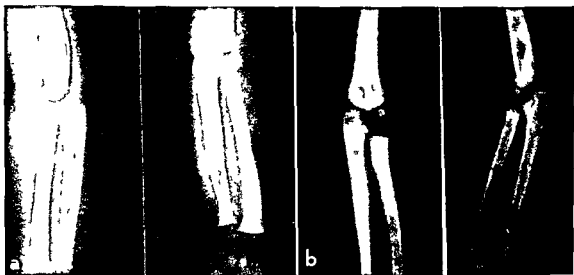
Osteochondritis and periostitis lueticum with pseudoparalysis. C. e. M. K. (female) #40 5973 eight months May 1940. Unable to use right arm for one month. Luetic stigmata of nose and mouth hydrocephalus Wassermann Kahn and Klein positive. X-ray shows periosteal thickening of the humeri ulnae and radii. Treatment with bismuth and arphenamine prompt response. a) Before treatment May 1940 b) After treatment November 1940 (Courtesy Dept. of Pediatrics State University of Iowa)
